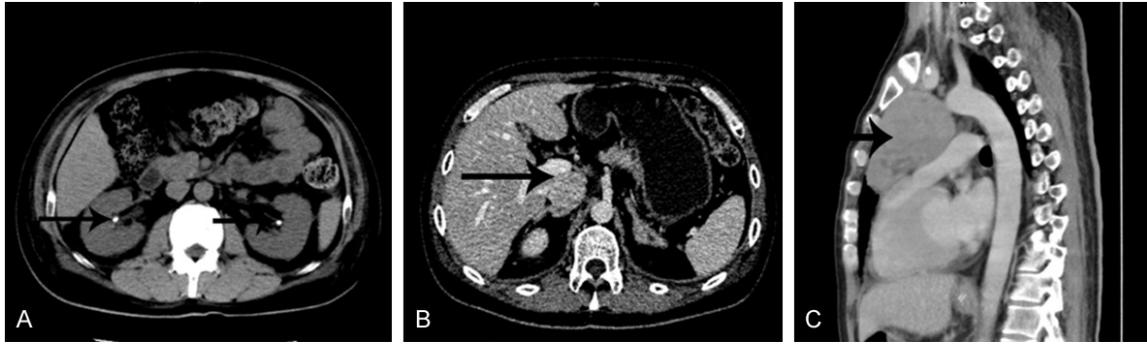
CT scan with enhancement, of lower and upper abdomen and chest, February 5, 2015. A: Multiple small stones are visible in both kidneys; B: Two nodules are visible in the pancreatic head region; there is bilateral adrenal gland enlargement, with the possibility of hyperplasia; C: Upper mediastinal mass, possibly an invasive thymoma.
